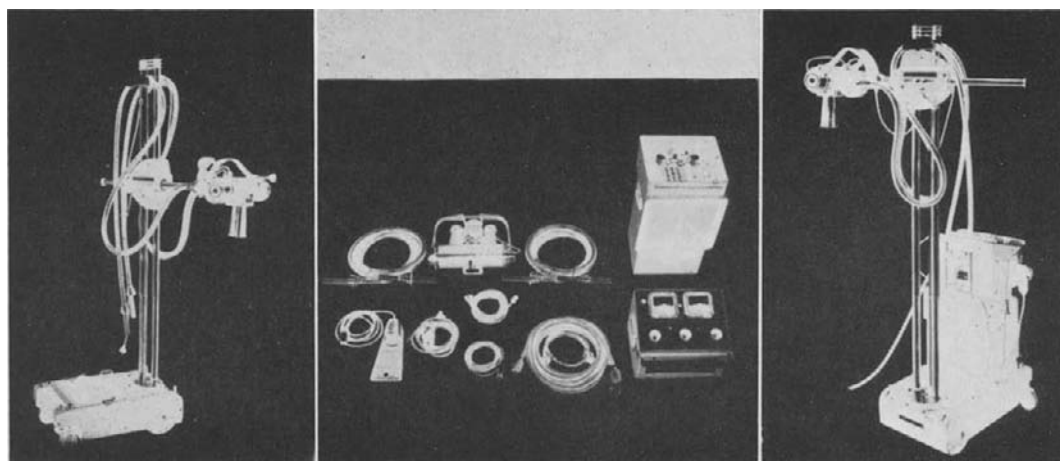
X-ray machine unit and the mobile x-ray chassis. The figure to the left shows the chassis unit complete with a tube unit, cone, and pair of shock-proof cables. All of these parts will be included with this unit as supplied in times of war. Otherwise, the tube unit and cables shown with the x-ray machine unit (middle figure) will be assembled as needed. The figure to the right shows the complete assemblage as this unit would be used for ward work.
